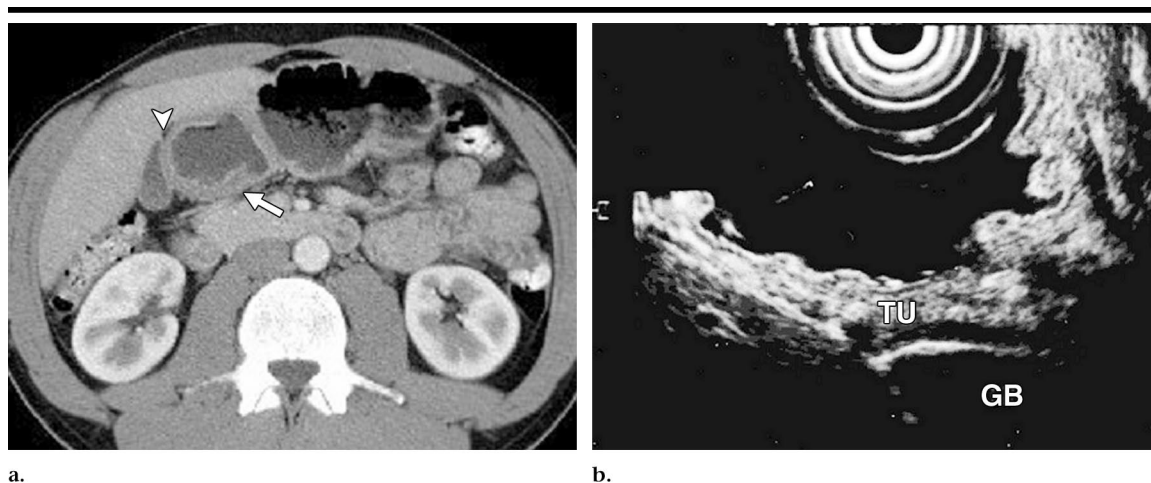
Images of a 73-year-old man. (a) Transverse CT image of an antral transmurial tumor close to the gallbladder (arrow) with no infiltration of the gallbladder and no visible blurring (arrowhead). This tumor was staged as T2. (b) Endoscopic US image of the tumor (TU) in a corresponding plane with a transmurial lesion and no wall thickening of the gallbladder (GB). This tumor was staged correctly as T2.
